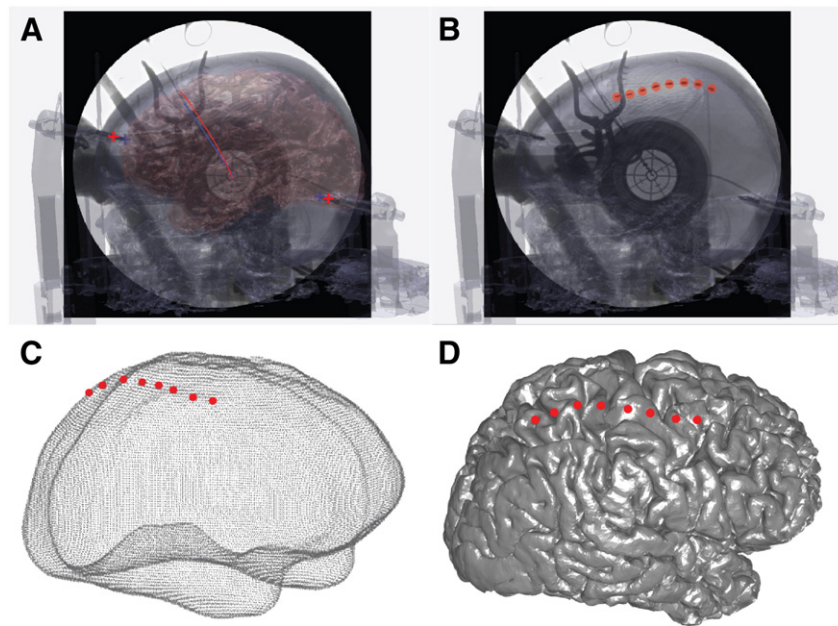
Electrode localization on cortex. (A) Coregistered CT and MRI surfaces with fluoroscopic image from translational and rotational manipulations of the CT and MRI surfaces to align the marked landmarks of the DBS electrode paths and stereotactic frame pins. (B) Electrode positions marked on the fluoroscopic image. (C) Intersection points of the line created orthogonal to the electrode positions with the smoothed cortical hull. (D) Electrode locations projected and visualized on a reconstructed cortical surface.
